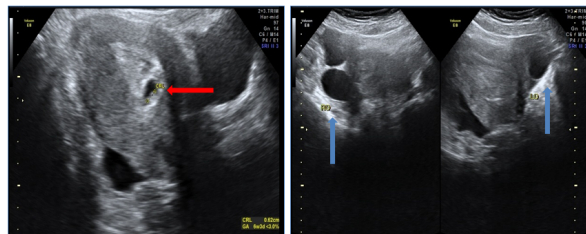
Figure I and II: Ultrasonography performed at 6 weeks 3 days revealed a single intrauterine gestation of 6 weeks 3 days with cardiac activity (red arrow) and both ovaries were normal with multiple follicles (blue arrow) and a cystic structure within the left ovary which was labeled as corpus luteal cyst. No evidence of any adnexal lesion or collection was noted.
